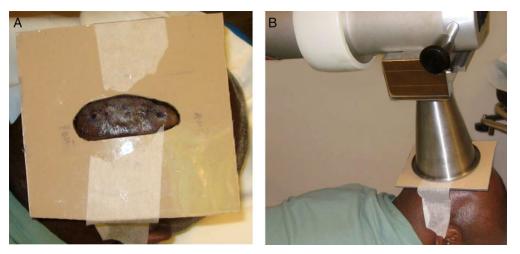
(A) A 48-year-old male who developed a keloid on his posterior scalp after a traumatic laceration is shown 12 hours after surgery for superficial X-ray radiation. The treatment field was confined to the keloid region, which includes the postoperative excision site plus and any suture/puncture holes with an approximate 0.5-1.0 cm horizontal margin to allow for setup uncertainties, horizontal nature of the target, and superficial x-ray penumbra. (B) The patient shown receiving his first fraction of superficial X-ray radiation 12 hours after surgery.
